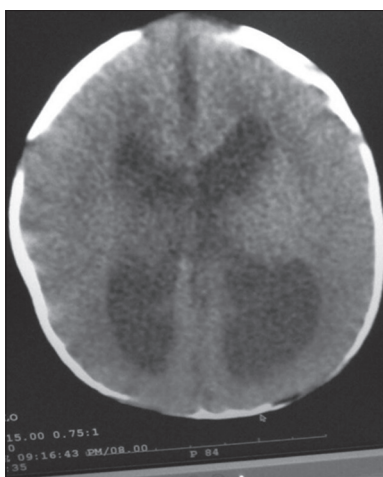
Axial section cranial noncontrast computed tomography scan performed at day 4 postspina bifida repair at first presentation showing dilated ventricles with effaced surface sulci
